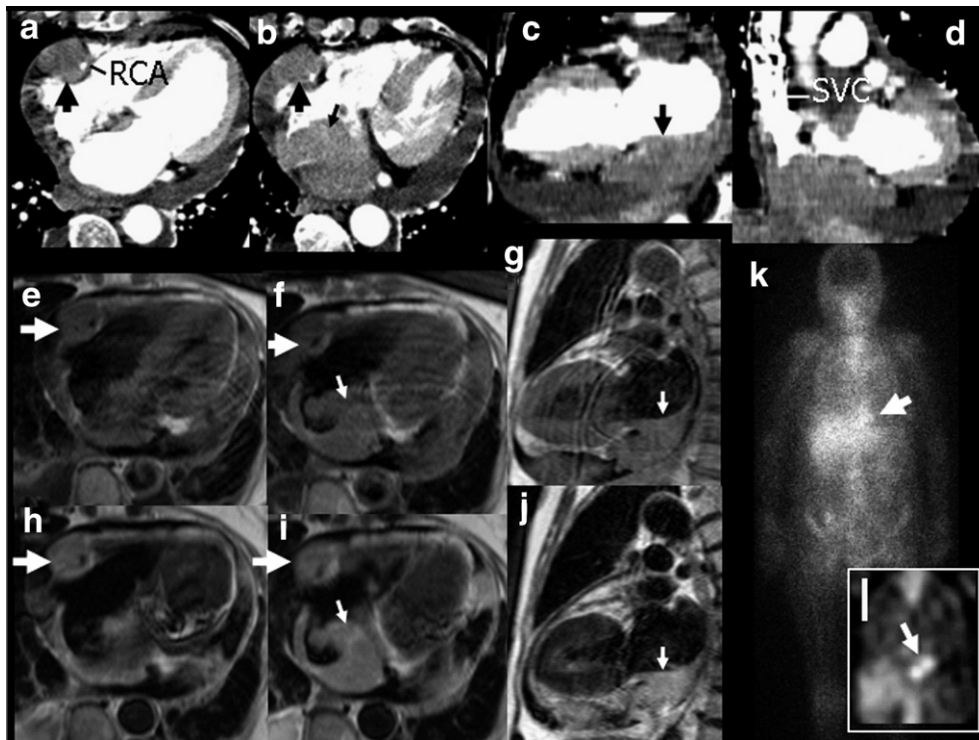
Contrast-enhanced multislice computed tomographic images on the horizontal axis (a, b) demonstrating non-contrast-enhanced masses in the right atrium (large arrows) which surrounds the right coronary artery (RCA) and in the bottom of the left atrium (small arrow). The long axis image (c) showing the mass in the left atrium (arrow). Coronal image (d) showing obstruction of the superior vena cava (SVC)–right atrium inflow tract by the tumor. T1-weighted magnetic resonance images on the axial (e, f) and long-axis (g) planes showing iso-intensity masses in the right (large arrows) and left atrium (small arrows). The masses are mildly high-intense on T2-weighted images (h–j). Planar (k) and tomographic (l) images of ⁶⁷Ga scintigram showing high isotope uptake in the heart (arrows).
